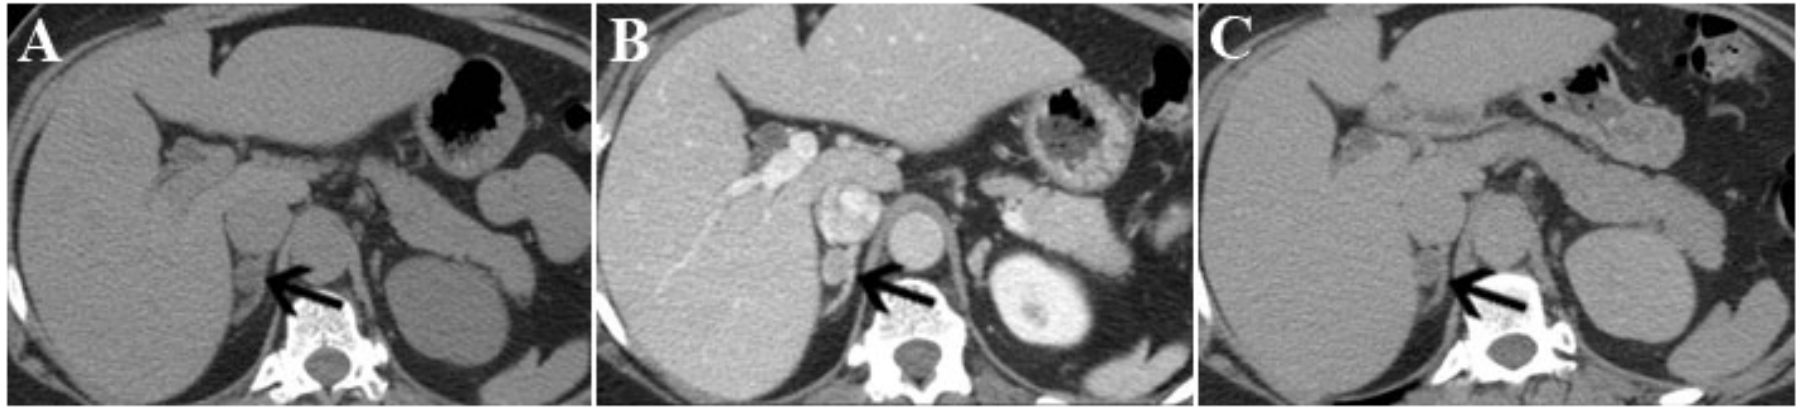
Axial images from an adrenal mass protocol CT scan performed to characterize an incidentally discovered right adrenal mass in a 48 year old woman. (A) The attenuation of the adrenal mass (arrow) in the unenhanced scan was 15 HU, which is indeterminate and could indicate a lipid-poor adenoma or a malignant lesion. (B) In the dynamic contrast-enhanced scan the mass (arrow) had an attenuation of 80 HU and (C) in the delayed washout scan, performed 10 minutes later, the mass (arrow) had an attenuation of 30 HU. The absolute adrenal washout rate was calculated to be 71.7% and the rel
